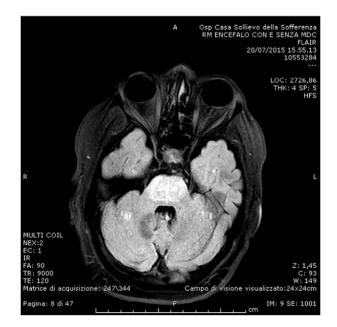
Isolated involvement of the entire pons in FLAIR sequences at entry MRI.
